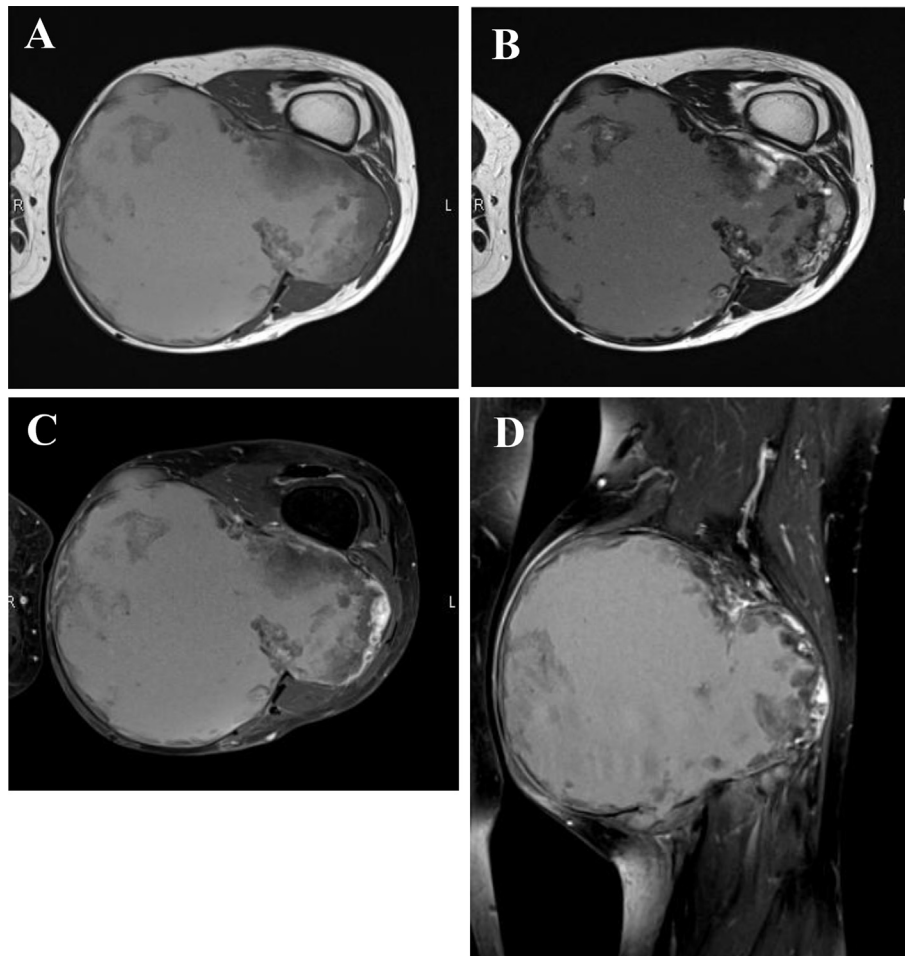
Magnetic resonance (MR) imaging. (A, B, and C) Axial view of T1-weighted image (A), T2-weighted image (B), and gadolinium-enhanced T1-weighted image (C). (D) Coronal view of gadolinium-enhanced T1-weighted image.
